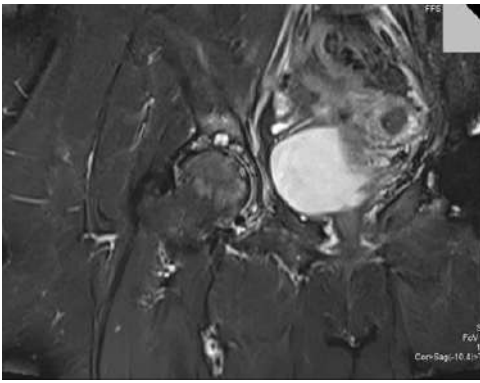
MRI of the right hip joint(November 2020) - showed features of degenerative changes evidenced by
